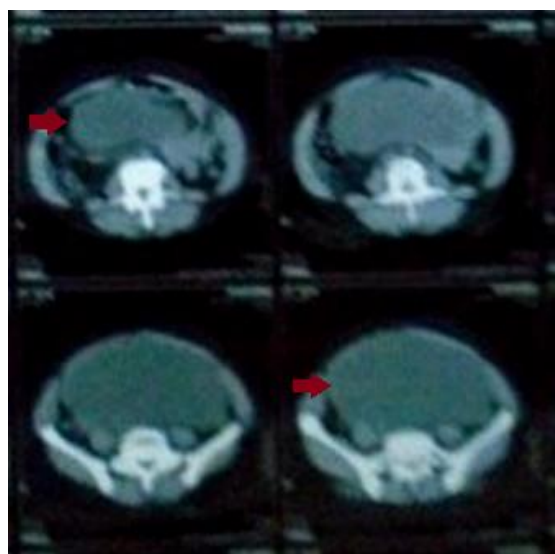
CT showing huge cyst in the pelvis(arrow)
